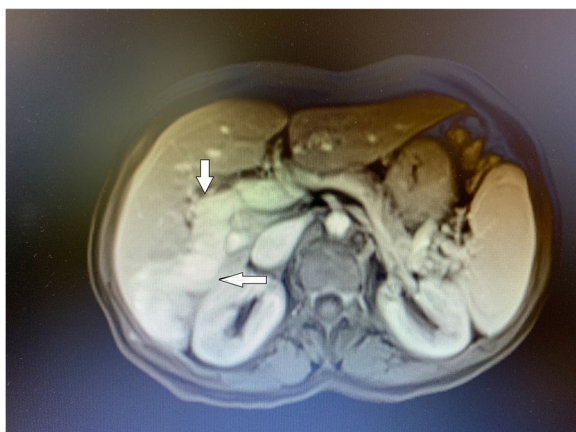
Abdominal MRI shows shunts between right portal vein and right hepatic vein in liver and large collateral venous structures
